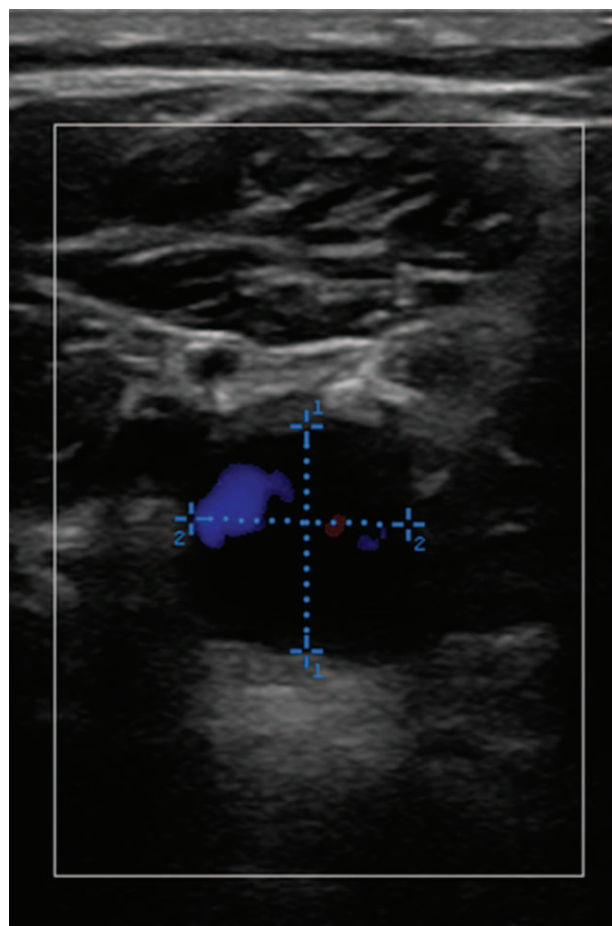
Color-coded duplex ultrasonography of the bypass graft's aneurysm with a size of 1.4 × 1.35 cm.
